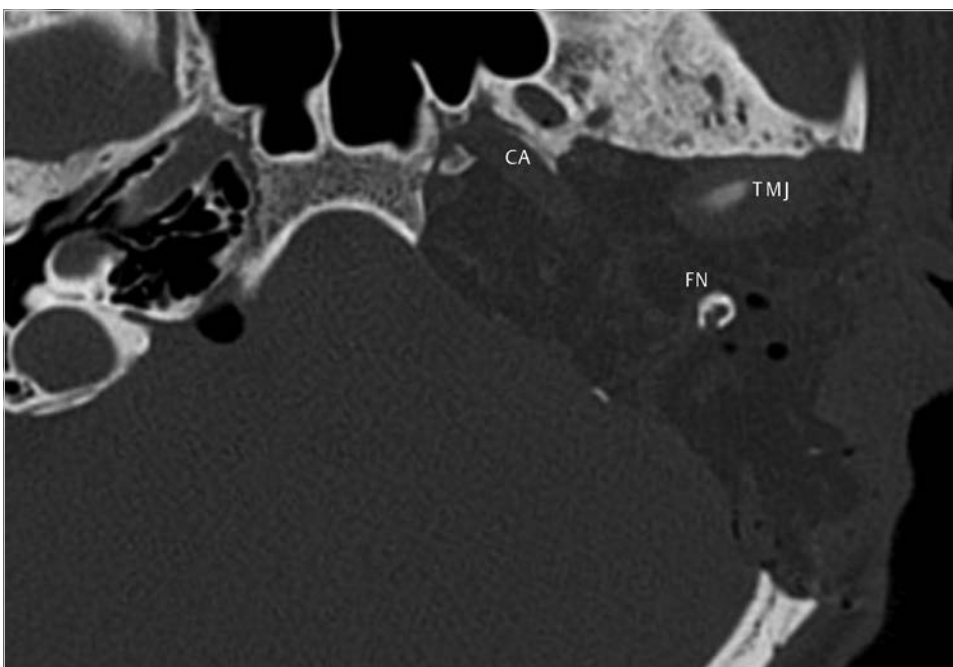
The postoperative CT shows extensive removal of bone from the temporal bone. The axial section demonstrates carotid artery, temporomandibular joint, and the facial nerve in the fallopian canal in the abdominal fat. Note that the drilling reached the area close to the sphenoid sinus. CA, carotid artery; FN, facial nerve; TMJ, temporomandibular joint.
